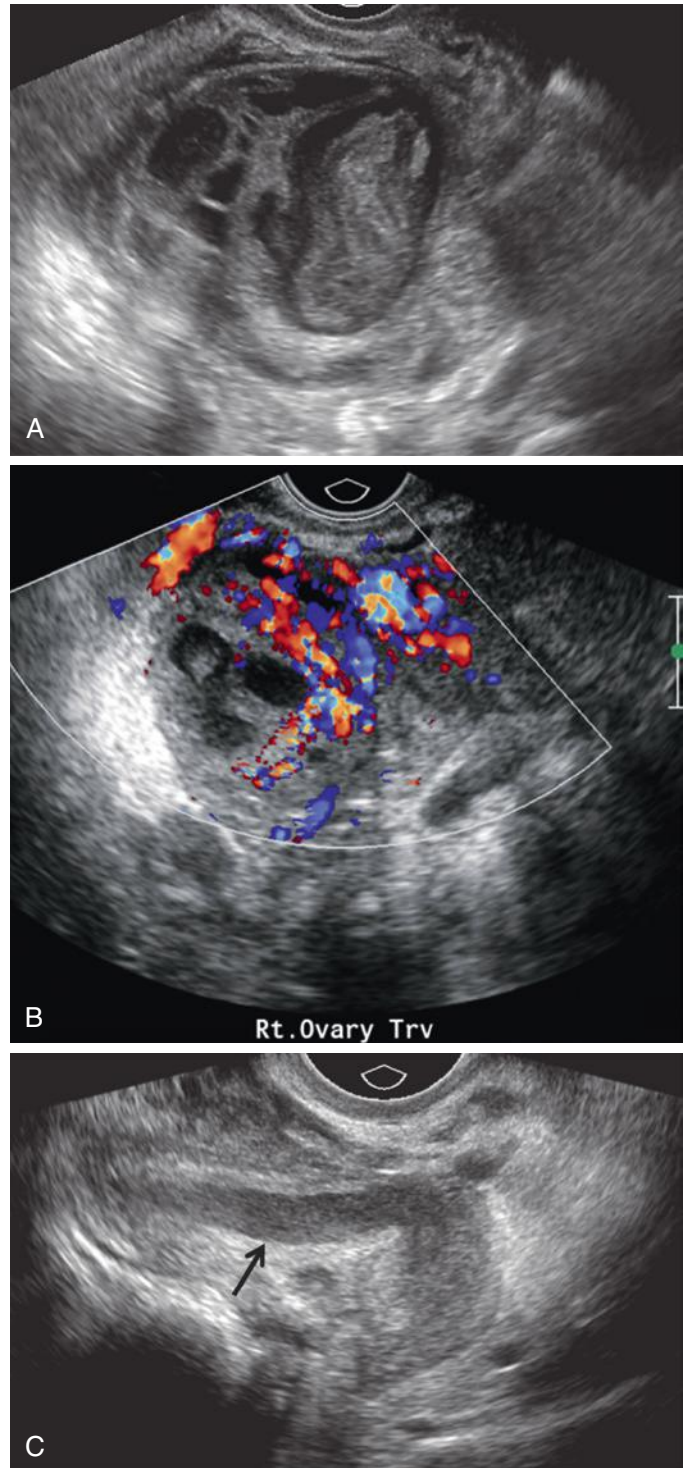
Tubo-ovarian abscess. A 27-year-old woman presented with bilateral pelvic pain and purulent vaginal discharge. A, Gray-scale image of the right adnexa demonstrating a complex, tender adnexal mass that was markedly vascular on color Doppler imaging (B). C, Note mildly dilated thick-walled adjacent pyosalpinx (*arrow*) and increased echogenicity of the adjacent pelvic fat. (Images courtesy of Dr. Margarita Revzin, Yale University School of Medicine, New Haven, CT.)
